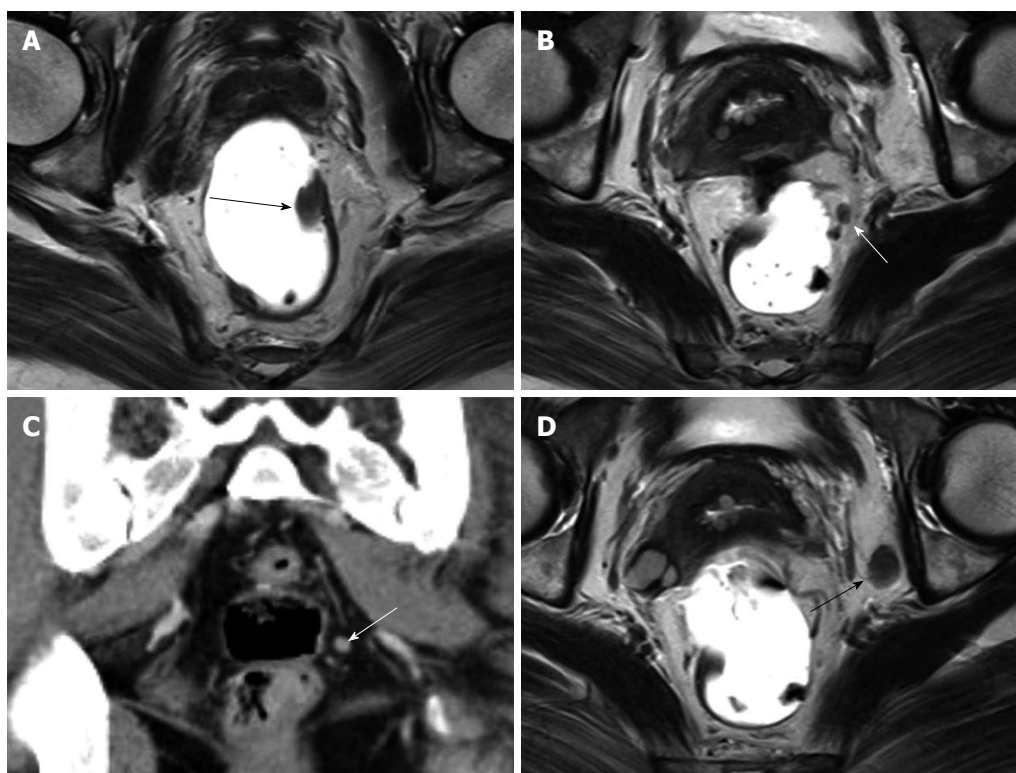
Early rectal carcinoma and lymph node metastasis on computed tomography and magnetic resonance imaging. A: Axial T2-weighted image shows polypoid rectal carcinoma (black arrow); B: Axial T2-weighted image shows perirectal lymph node (white arrow); C: Coronal computed tomography scan shows the same lymph node (white arrow); D: Axial T2-weighted image shows an enlarged left obturator lymph node (black arrow). These metastatic lymph nodes were one-to-one correlated pathologically.
